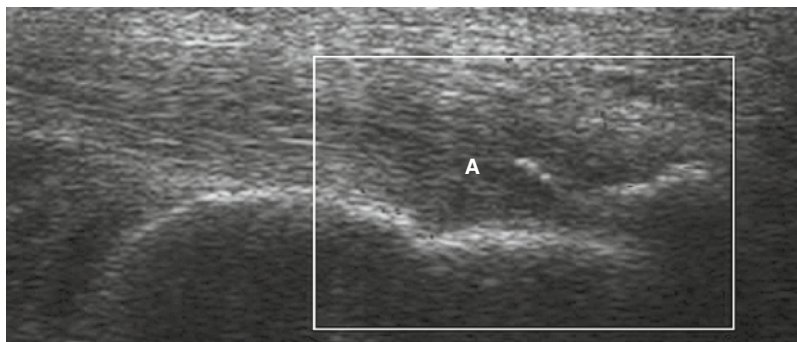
A longitudinal ultrasound scan identifies erosion (A) of Achilles tendon enthesitis.
